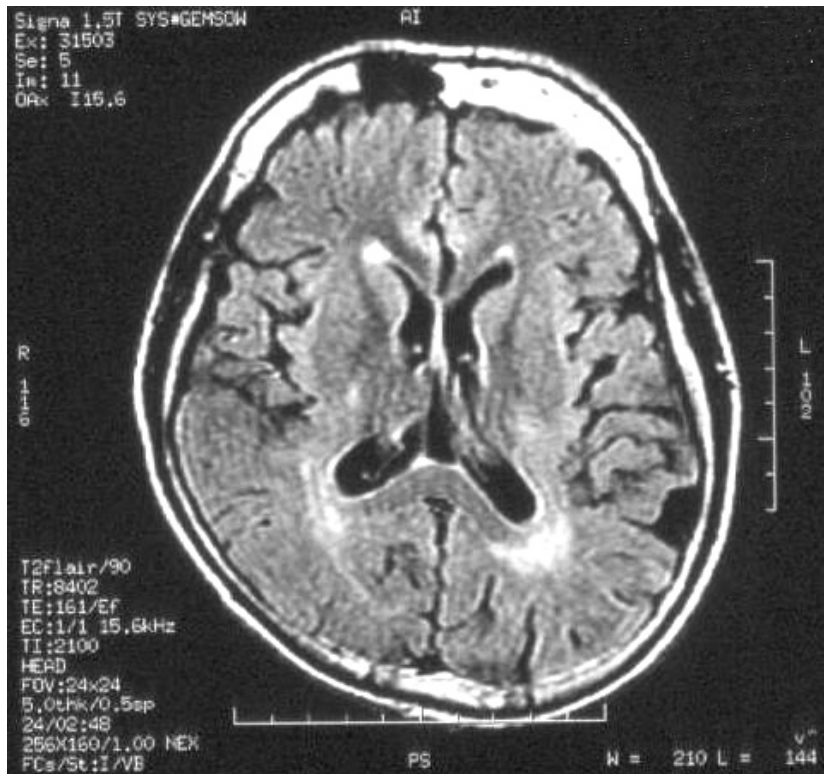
The MR images revealing periventricular white matter hyperintensities on FLAIR sequences.
